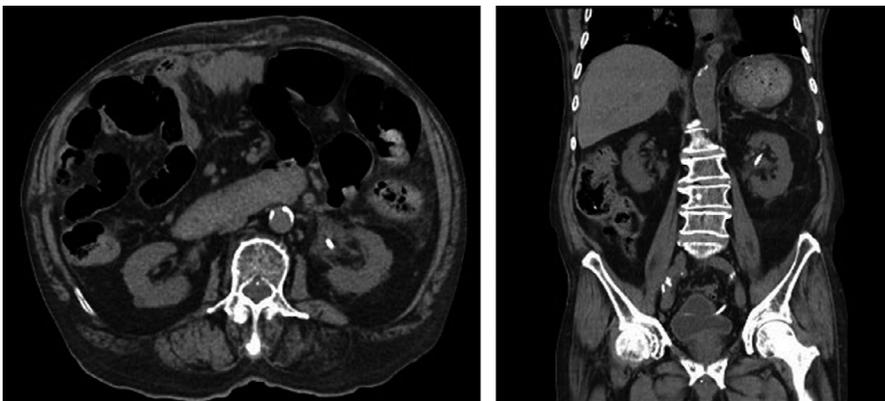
Two-month post-operative computation tomography (CT). CT images demonstrated regression of left retroperitoneal fibrosis and hydronephrosis
